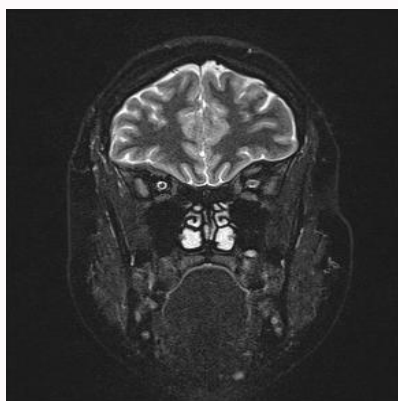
MRI, STIR sequence, showing optic neuritis of the left eye.
